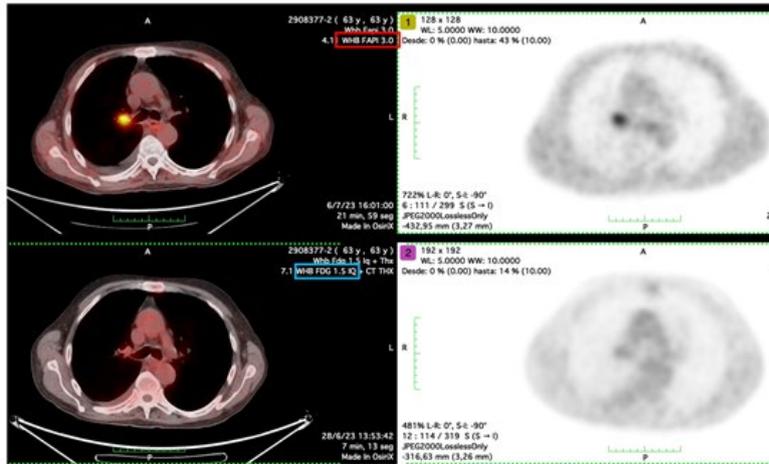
Patient with significant ⁶⁸Ga-FAPI-04 uptake in right hilar lymph node, previously undetected with ¹⁸F-FDG PET/CT
